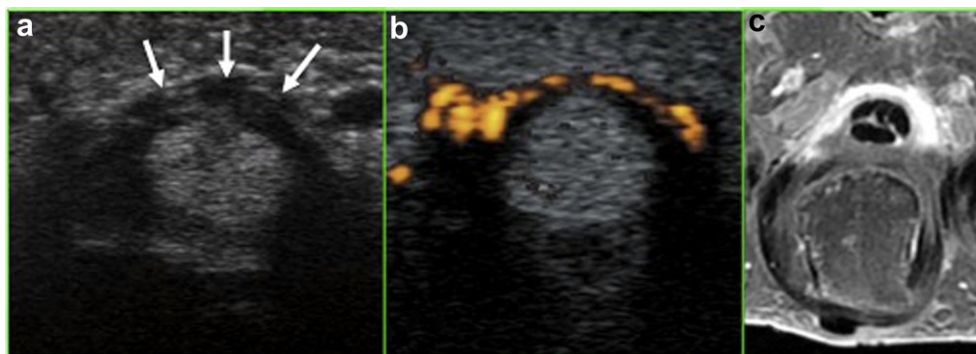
Trigger finger: Axial ultrasound image reveals hypertrophy of the A1 pulley (arrows) (a), hypervascularization on Doppler imaging (b), contrast uptake by the A1 pulley after injection of gadolinium during MR imaging (c).
